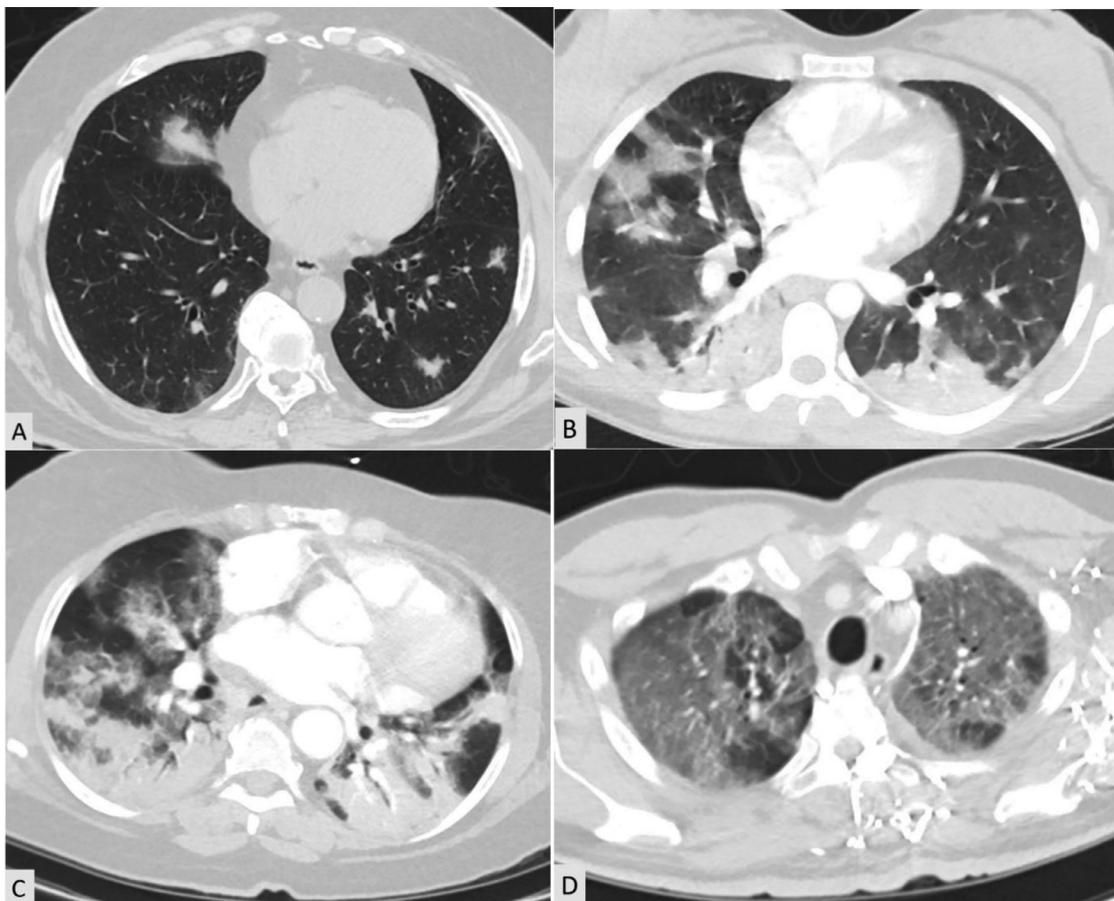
(A) Axial CT demonstrates mild acute COVID-19 with mild severity of peripheral-predominant ground-glass opacities and consolidation, with a rounded morphology in both lower lobes. (B) Axial CT demonstrates moderate acute COVID-19 with a moderate amount of ground-glass and dense consolidation in a peribular distribution; (C) Axial CT demonstrates severe acute COVID-19 with bilateral confluent consolidative opacities in a patient with cardiomegaly; (D) Axial CT demonstrates diffuse ground-glass opacities extending to the lung apices, seen in more severe disease and portending a poorer prognosis.
